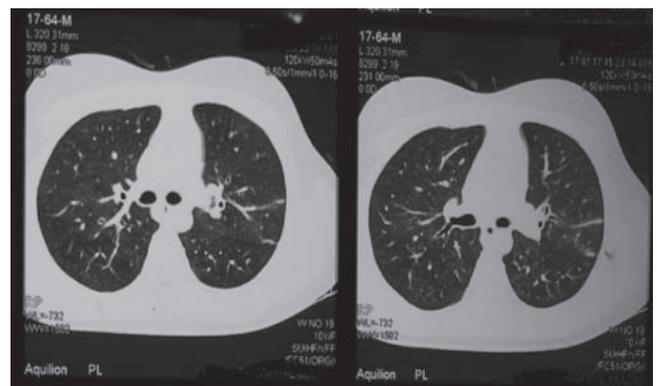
Follow-up HRCT scan of chest showing complete resolution of pulmonary infiltrates.
